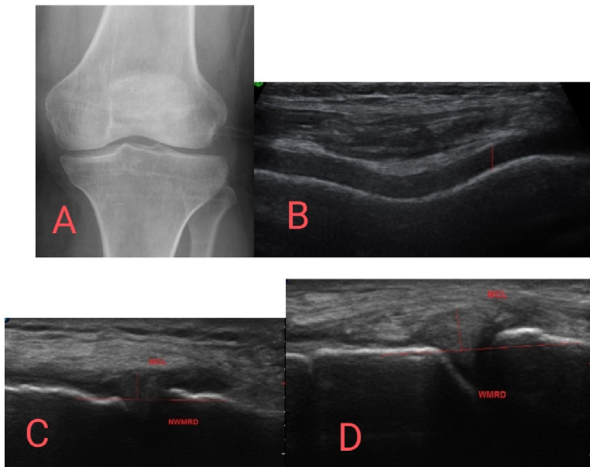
Male patient 66 years old, complaining of pain at the medial aspect of the left knee. (A) Lt knee radiograph AP view KL grade 1 (non-osteoarthritis), (B) US of medial compartment in supine position with flexed knee, cartilage thickness of medial femoral condyle 2.1 mm. (C) US of medial compartment supine position NW-MRD = 3.7 mm. (D) US of medial compartment (standing) W-MRD = 4.0 mm.
